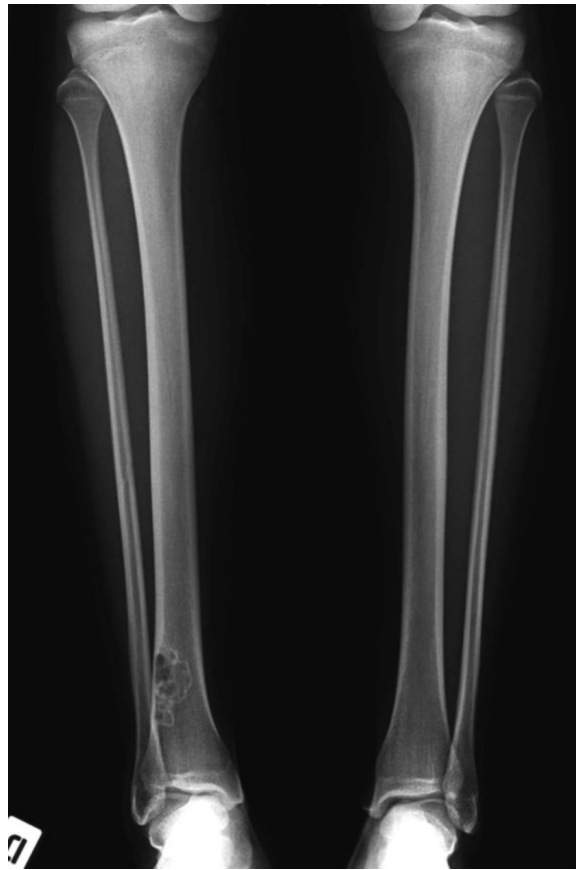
14-year-old girl with nonossifying fibroma. AP radiograph of both tibias, showing an eccentric, lucent lesion in the distal right tibia with a well-demarcated, sclerotic border, consistent with a nonossifying fibroma.
